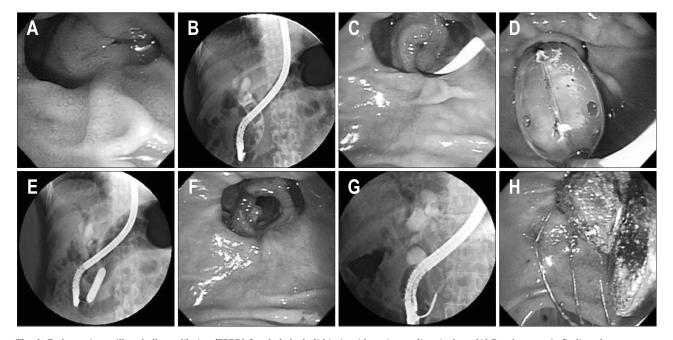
Endoscopic papillary balloon dilation (EPBD) for choledocholithiasis with perivater diverticulum. (A) Duodenoscopic finding shows an ampulla of Vater located in a diverticulum. (B) ERCP shows multiple stones in the common bile duct. (C) The guidewire is inserted into the bile duct. (D) The 10 mm balloon is gradually inflated with diluted contrast material; inflation is maintained for 30 seconds. (E) X-ray during balloon dilation shows complete disappearance of the sphincter waist. (F) Duodenoscopic finding after EPBD shows a well-visualized common bile duct with a large dilated opening of the sphincter of choledochus. (G) ERCP shows a stone grasped by a mechanical lithotripter. (H) Duodenoscopic finding shows stones removed from the common bile duct by a Dormia basket.
